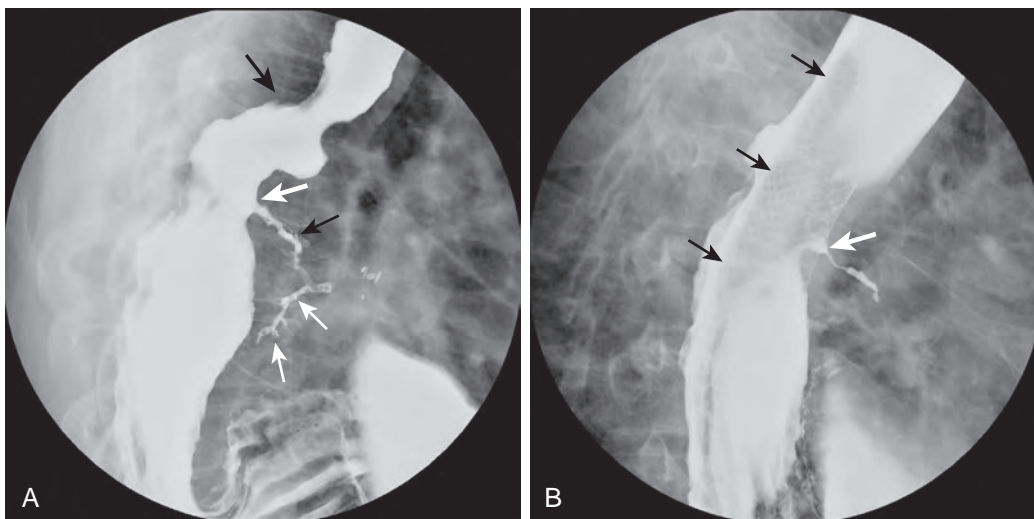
Fistula from postoperative stomach extending into the right lung. A. Spot radiograph centered near the esophagogastric anastomosis (*black arrows*) shows a fistula arising at a 3-mm diameter hole in the proximal stomach (*thick white arrow*) at its staple line. The leak fills subsegmental bronchi (*thin white arrows*). B. Spot radiograph obtained after a metallic stent (*black arrows*) was placed. Barium goes around and through the stent. Barium around the outside of the stent fills the fistula (*white arrow*).
